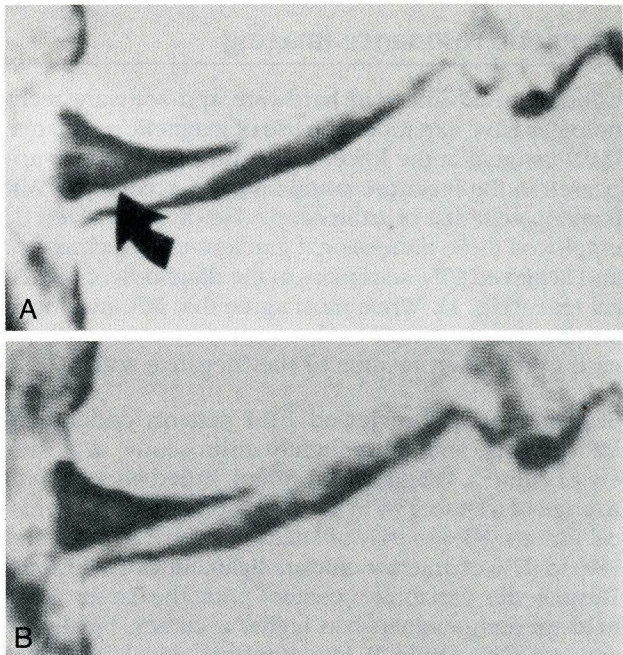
Coronal view of the lateral meniscus in a patient aged 24 years. A, The initial magnetic resonance image shows a grade 2 lesion in the body of the lateral meniscus (arrow). B, After a 1-year follow-up, the image obtained shows a decrease in the grade 2 abnormality. The imaging parameters were as follows: repetition time, 800 ms; echo time, 20 ms; matrix, 256 x 256; section thickness, 3 mm; no spacing. (From Dillon *et al.* [7••]; with permission.)
